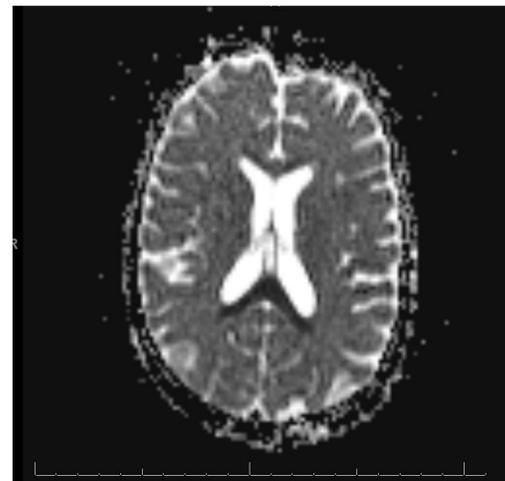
Brain MRI showed cytotoxic edema of the corpus callosum
